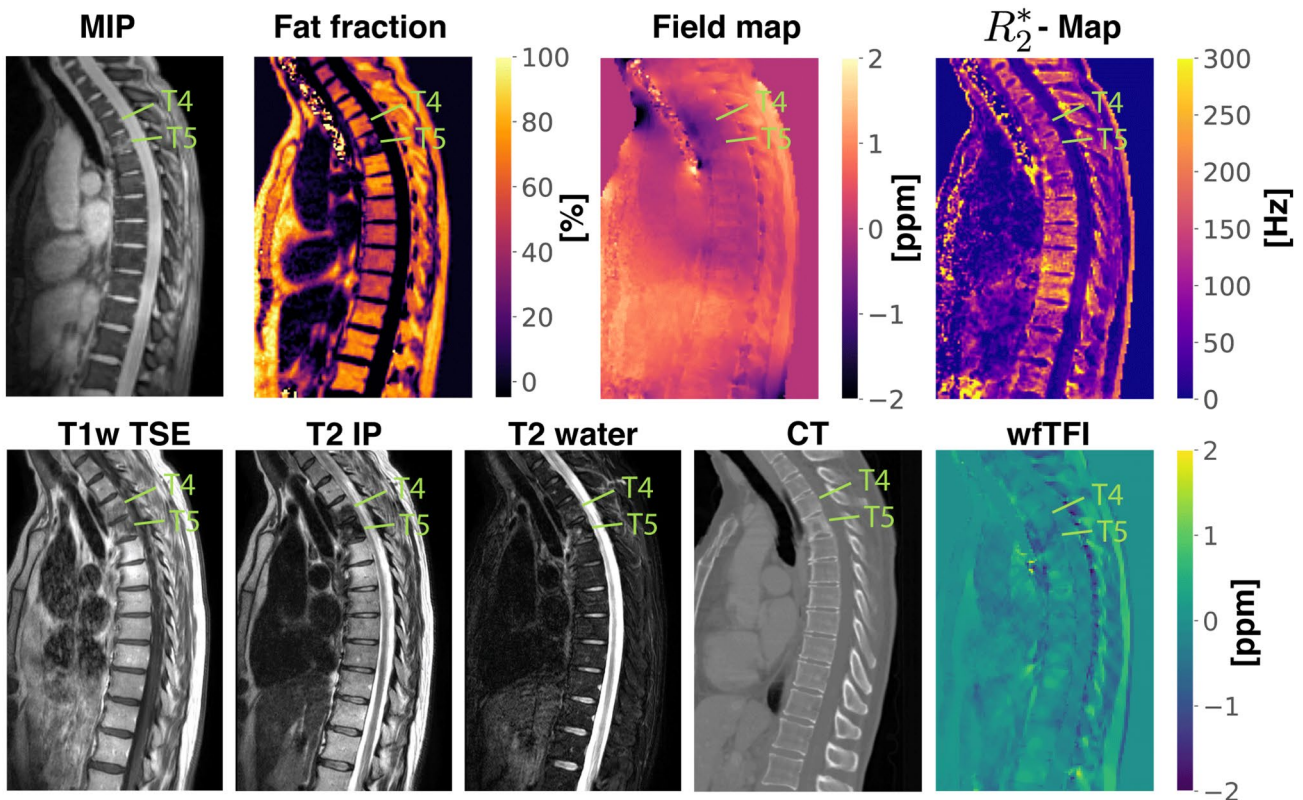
Results of water-fat imaging (first row), clinical T1w TSE, T2w IP, T2w water, CT, and QSM (second row) in a female patient diagnosed with renal cancer and mainly osteolytic bone metastases of the vertebrae T4 and T5 according to CT. The metastatic lesion appears T1- and T2-hypointense, thus suggesting an osteoblastic mass. The results of the wfTFI QSM method and the MIP, however, suggest an osteolytic pattern, therefore being in agreement with CT as the reference standard
